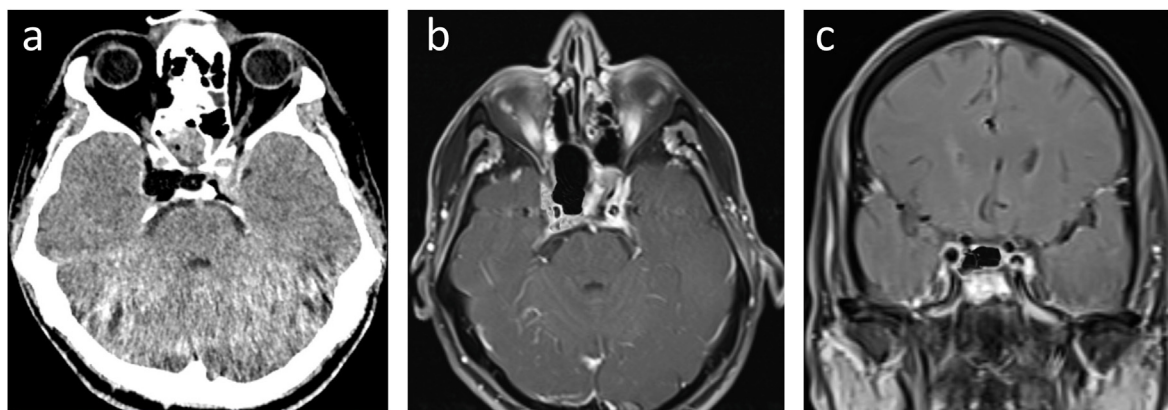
Postoperative imaging after tumor excision with endoscopic transsphenoidal approach a) Axial section b) axial image on contrast enhanced T1 MRI c) Coronal image on contrast enhanced T1 MRI.
